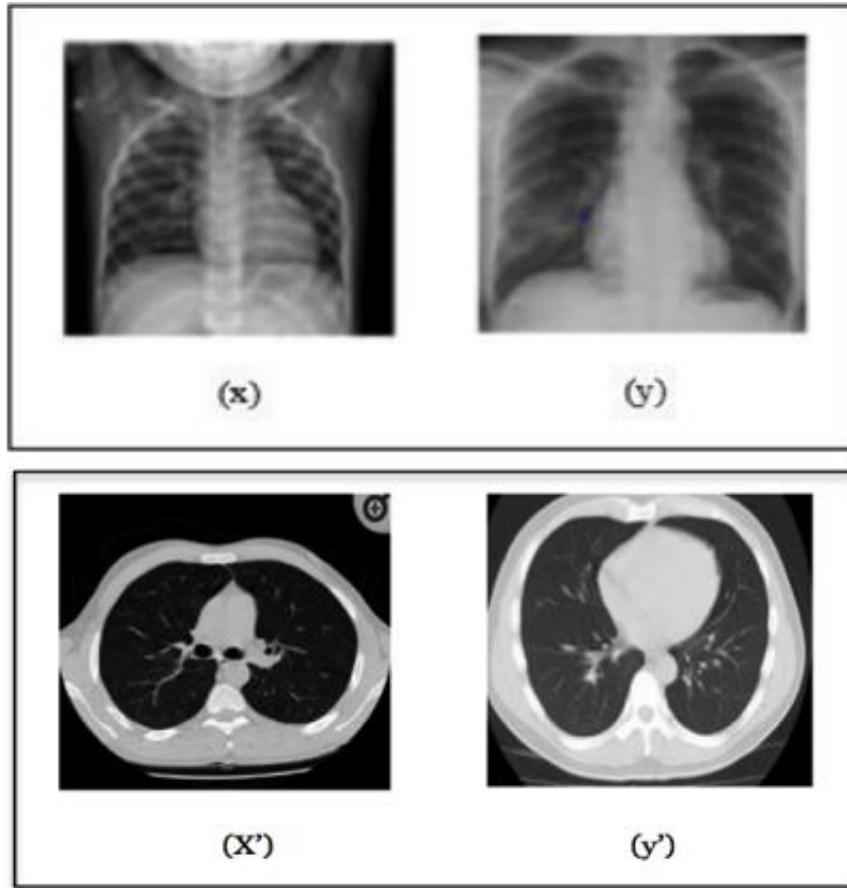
(x) Normal chest image and (y) Covid 19 affected chest image (x') Normal CT scan image and (y') COVID-19 affected CT scan image.
